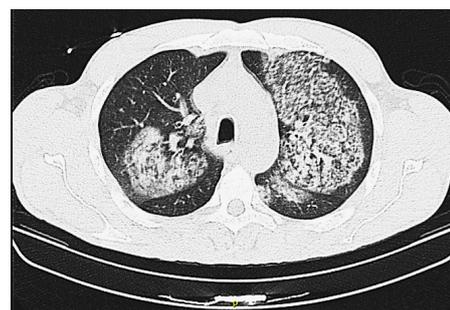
Representative chest CT showing diffuse intra-alveolar haemorrhage at the day of admission in emergency room.
